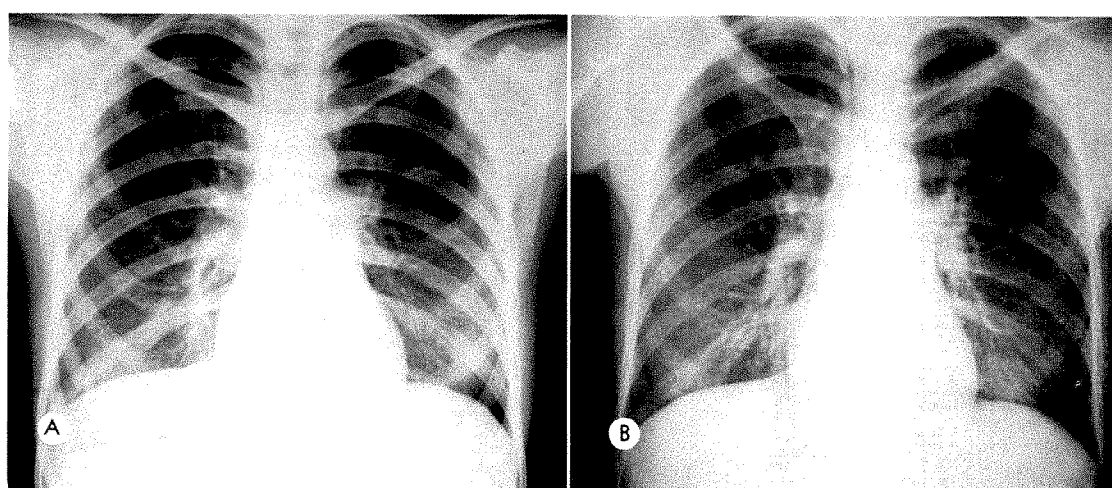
(A) Conventional posteroanterior chest roentgenograms of an average sized patient. (B) Posteroanterior chest roentgenogram made with the triad technique in the same patient. The greater detail in B is apparent.
